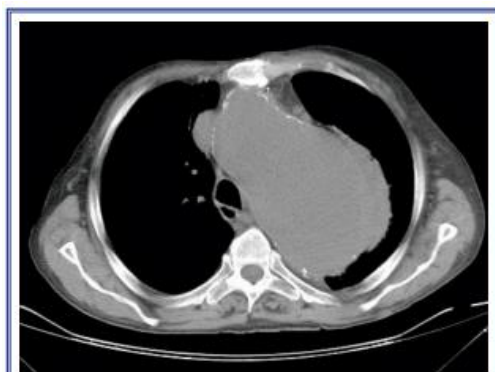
Contrast-enhanced thorax CT: an aortic aneurysm with its largest diameter approaching 120 mm situated on the aortic arch with heterogeneous non-calcific atheromatous plaques on the lateral aspect, and a peripheral mass consistent with a hematoma
